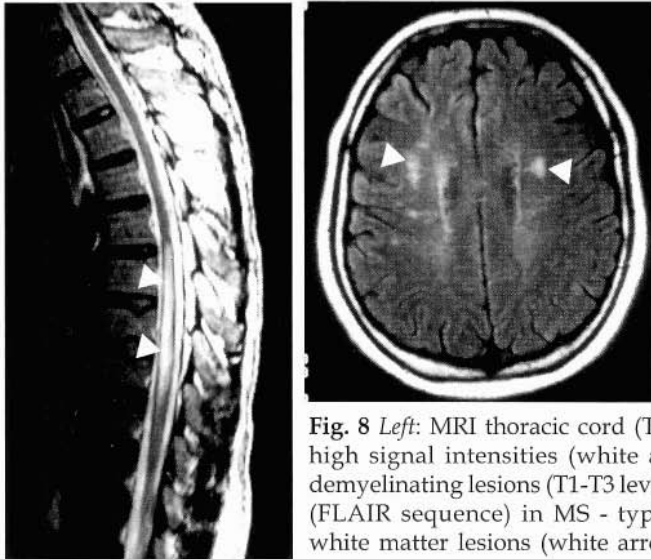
Left:* MRI thoracic cord (T2 sequence) in MS - high signal intensities (white arrowheads) due to demyelinating lesions (T1-T3 levels). *Right:* MRI brain (FLAIR sequence) in MS - typical periventricular white matter lesions (white arrowheads).
